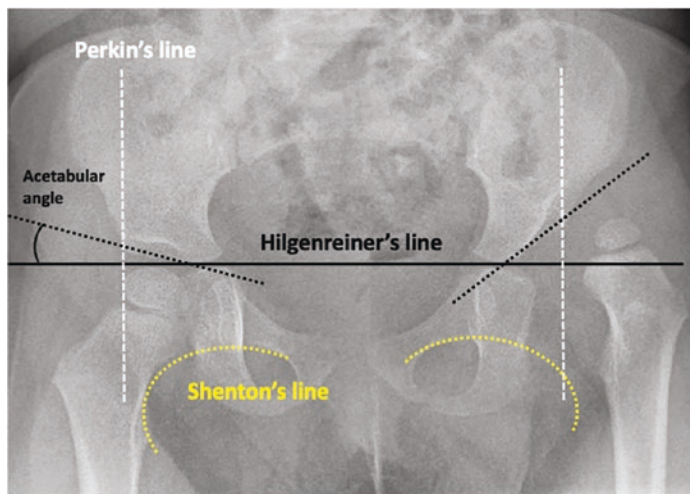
Anteroposterior radiograph showing Hilgenreiner's, Perkin's, and Shenton's lines, and the acetabular angle. There is developmental dysplasia of the left hip with increased acetabular angle, a shallow acetabulum, and dislocation. Note delayed ossification of the left femoral head epiphysis. The right hip joint is normal. (Permission from Herregods et al. [1])
